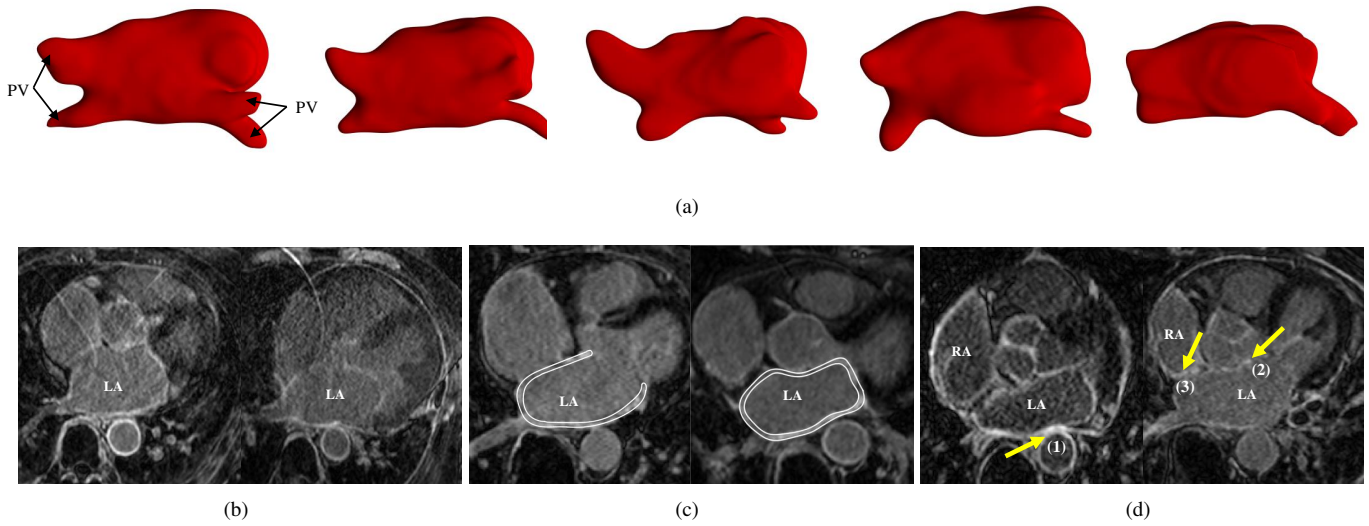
The challenges of automatic segmentation and quantification of LGE MRI for AF: (a) various LA and pulmonary vein (PV) shapes; (b) two typical LGE MRIs with poor quality; (c) thin atrial walls highlighted using bright white color in the figure; (d) surrounding enhanced regions pointed out by the arrows, where (1) and (2) indicate the enhanced walls of descending and ascending aorta, respectively; and (3) denotes the enhanced walls of right atrium (RA). Images (b)-(d) adopted from Li *et al.* (2020b).
